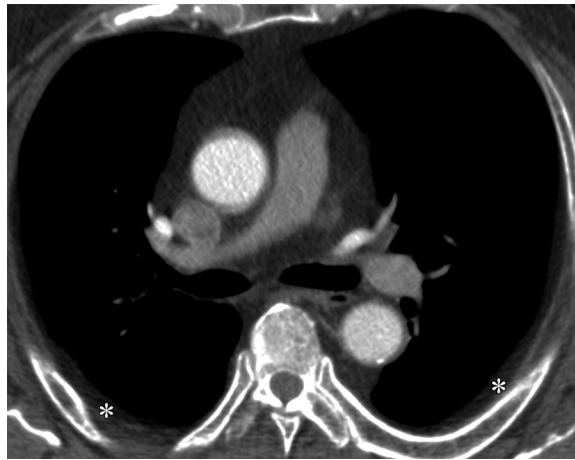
Nonpathologic extrapleural adipose tissue in an obese patient. Axial CT image shows increased adipose deposits (*) in the EPS.
